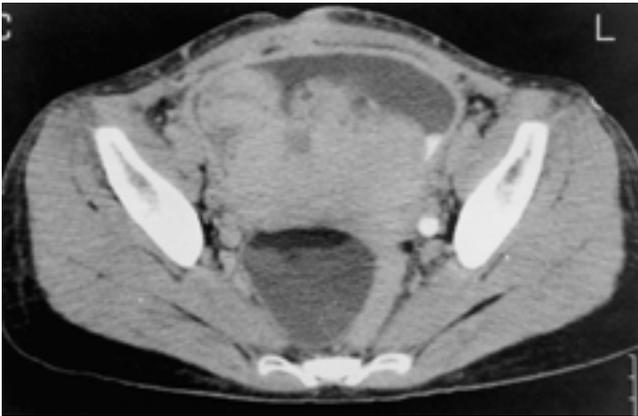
A. Precontrast CT scan shows large intravesical mass.
